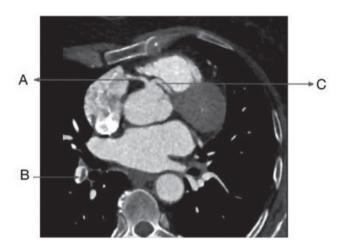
CT angiography image of the left main coronary artery originating from the right coronary cusp.
